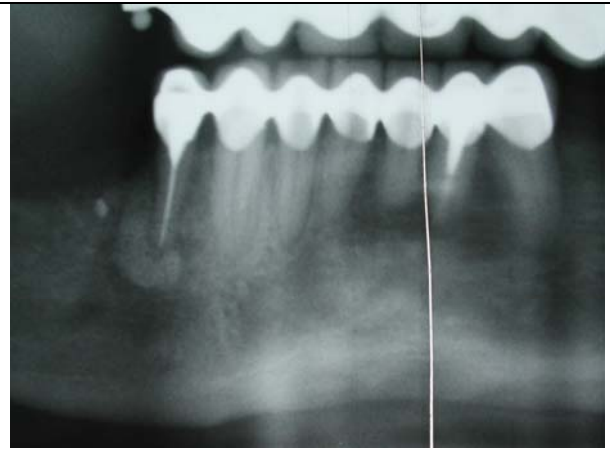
Panoramic radiograph after root resection of 44 and with defect filled with Cerasorb.
